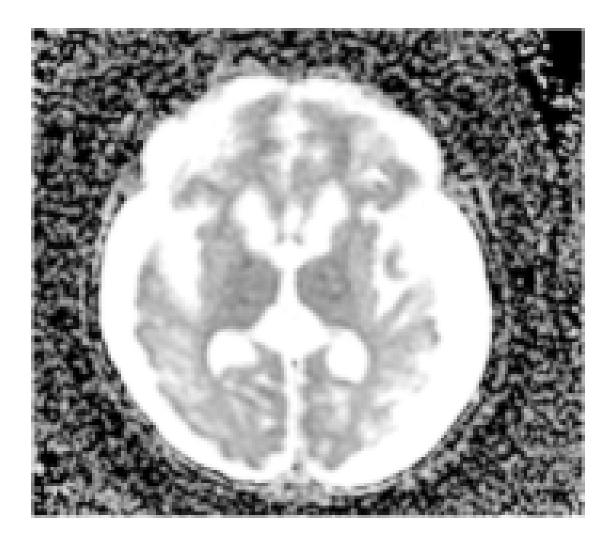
MRI brain without contrast showing Linear 71 and T2 signal abnormality throughout the subcortical white matter and basel ganglia signal abnormality.
